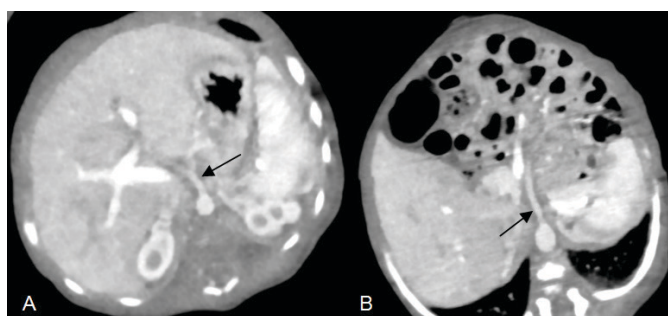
Axial view CT angiography shows opacification of both the coeliac trunk and the superior mesenteric artery.
